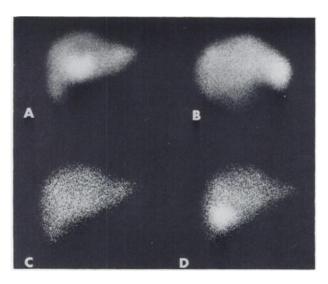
A and B are anterior and right lateral liver scans obtained after pom*Tc-sulfur colloid injection. There is hot spot situated at junction of right and left lobes near anterior surface of liver. C and D are anterior scintigrams of liver of same patient obtained on next day, 15 and 30 min after 1311-rose bengal injection. Only radioactivity in gallbladder became visible on 30-min scan.
